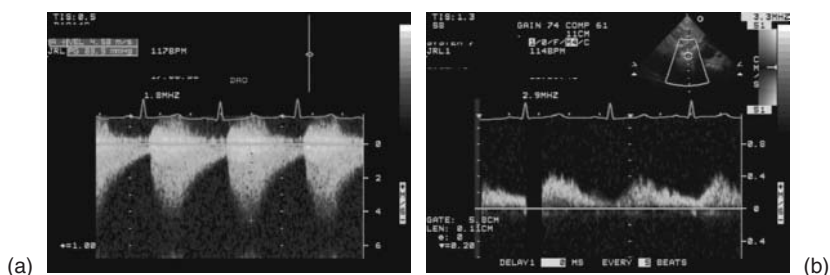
Echo Doppler images suggesting coarctation. (a) Continuous wave Doppler showing increased peak velocity with antegrade diastolic run-off through the area of coarctation. (b) Blunted abdominal aortic flow.
